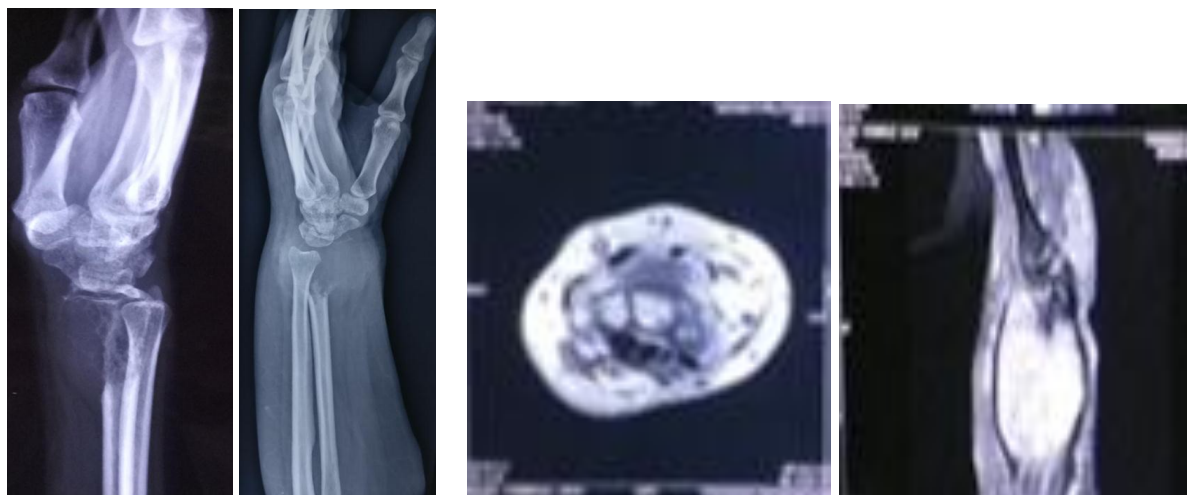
Pre-operative X-ray and MRI showing GCT of distal end radius (case-2)
